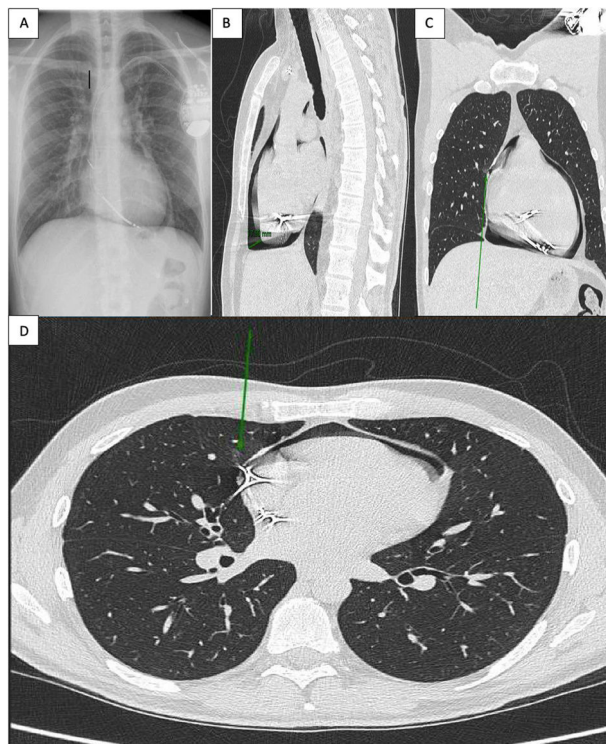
Posterolateral chest radiography (A). Sagittal section chest computed tomography (B). Coronal and cross-section chest computed tomography (C and D) showing atrial and pleural perforation by pacemaker lead (arrows).
